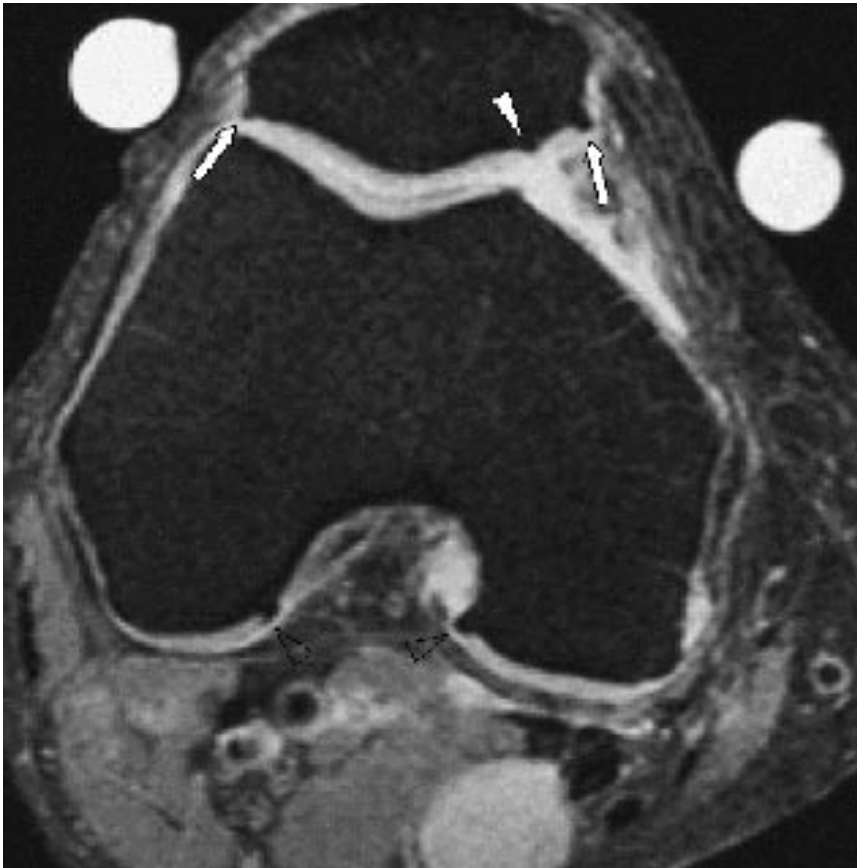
Axial turbo spin echo MR image. All three types of osteophytes are appreciated on this image: marginal osteophytes (arrows), intercondylar osteophytes (open arrowhead) and a central osteophyte (filled arrowhead)
